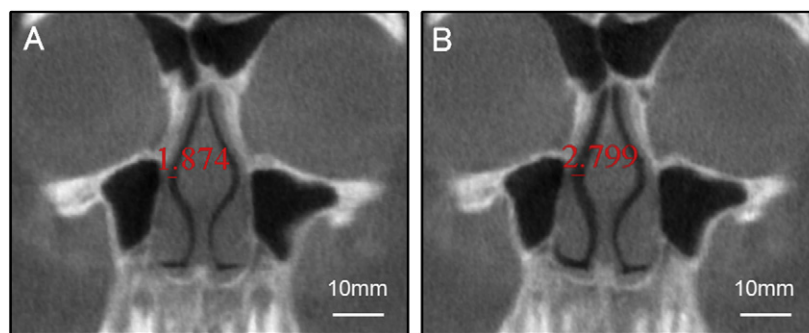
Cone-beam computed tomography images of a patient with a nasal width expansion of 2 mm (A, before rapid maxillary expansion; B, after rapid maxillary expansion): A, the greatest width of the nasal cavity was comparatively narrow; B, the greatest width of the nasal cavity was expanded approximately 1 mm. This was enough expansion of nasal cavity area; however, evaluation of nasal airway ventilation improvement was difficult with the morphologic data alone.
